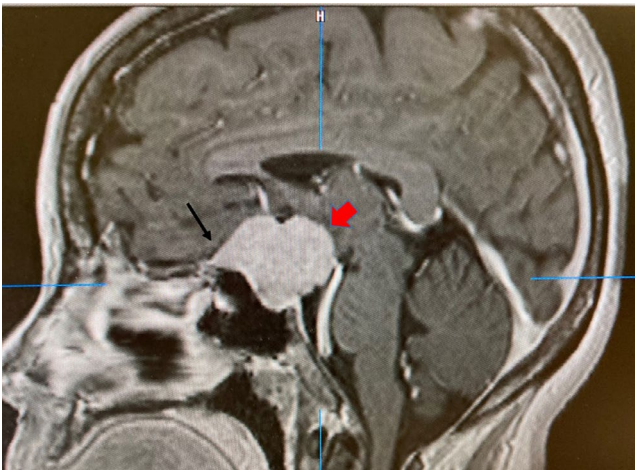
Preoperative contrast T1, sagittal MRI of the extra-axial suprasellar meningioma (Broad red arrow). The tumor occupies the sellar region with some suprasellar extension. Note anteriorly the dural tail finding characteristic of meningiomas (thin black arrow)
